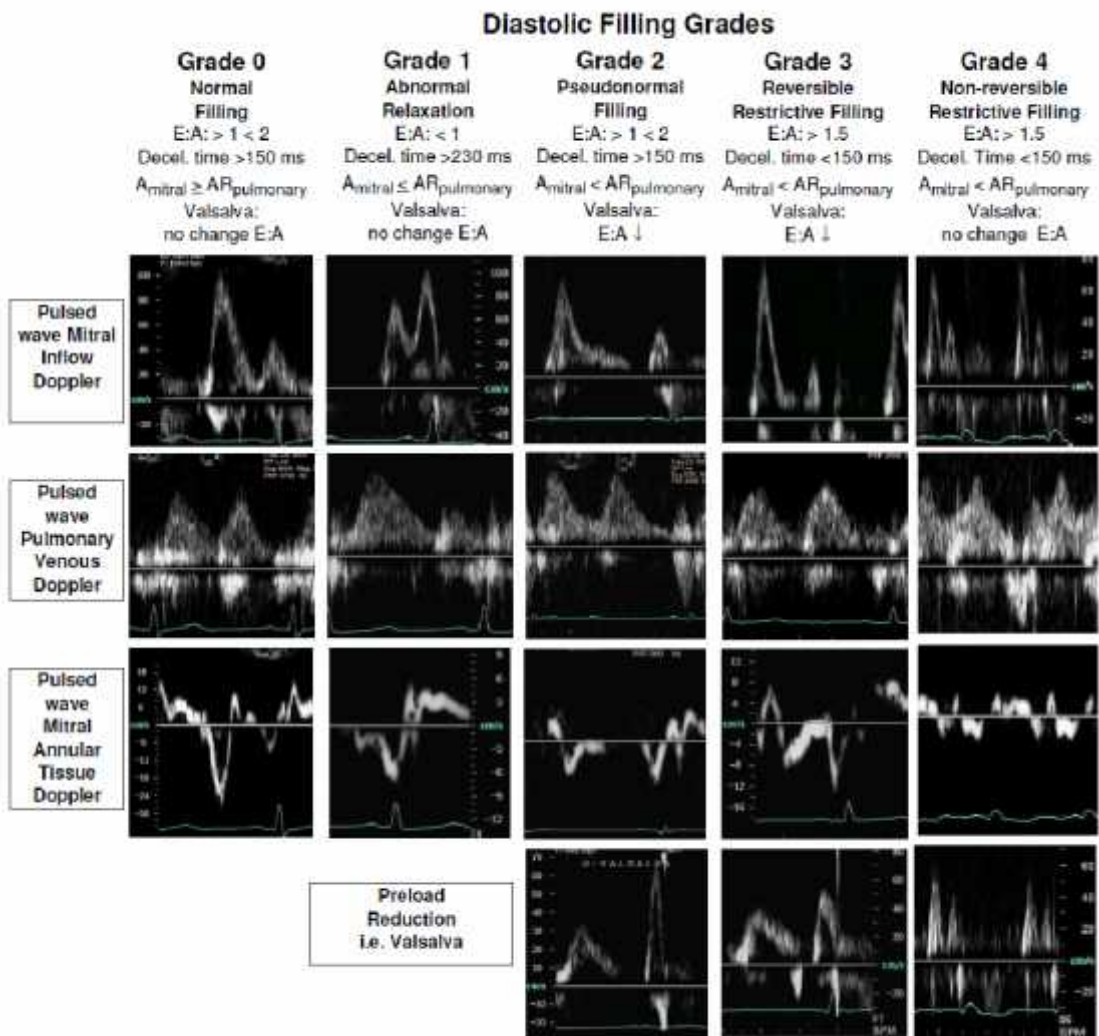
Diastolic filling grades based upon mitral, pulmonary and mitral annular pulsed wave doppler
